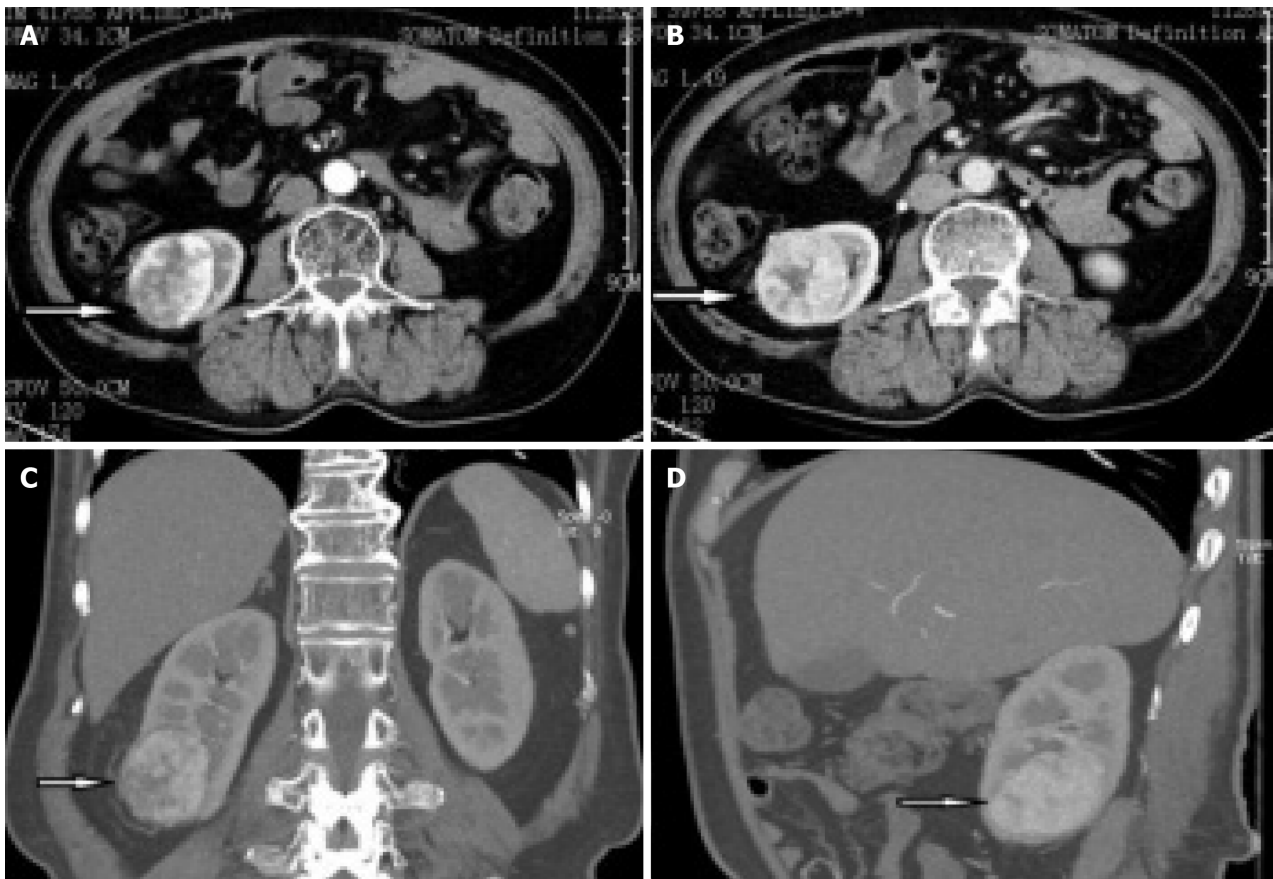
Abdominal contrast-enhanced computed tomography scans revealed that a heterogeneous mass was seen in the lower pole of the right kidney, with the size of about 53 mm × 47 mm. A: Arterial phase; B: Venous phase; C: Coronal section; D: Median sagittal section.
